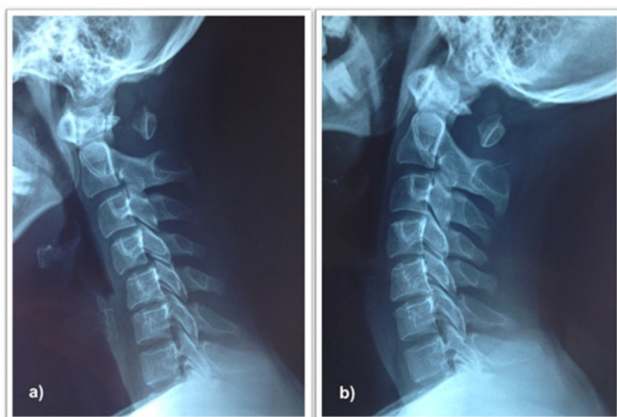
Dynamic radiographs of the cervical spine, showing a defect in the posterior arch of the atlas.
